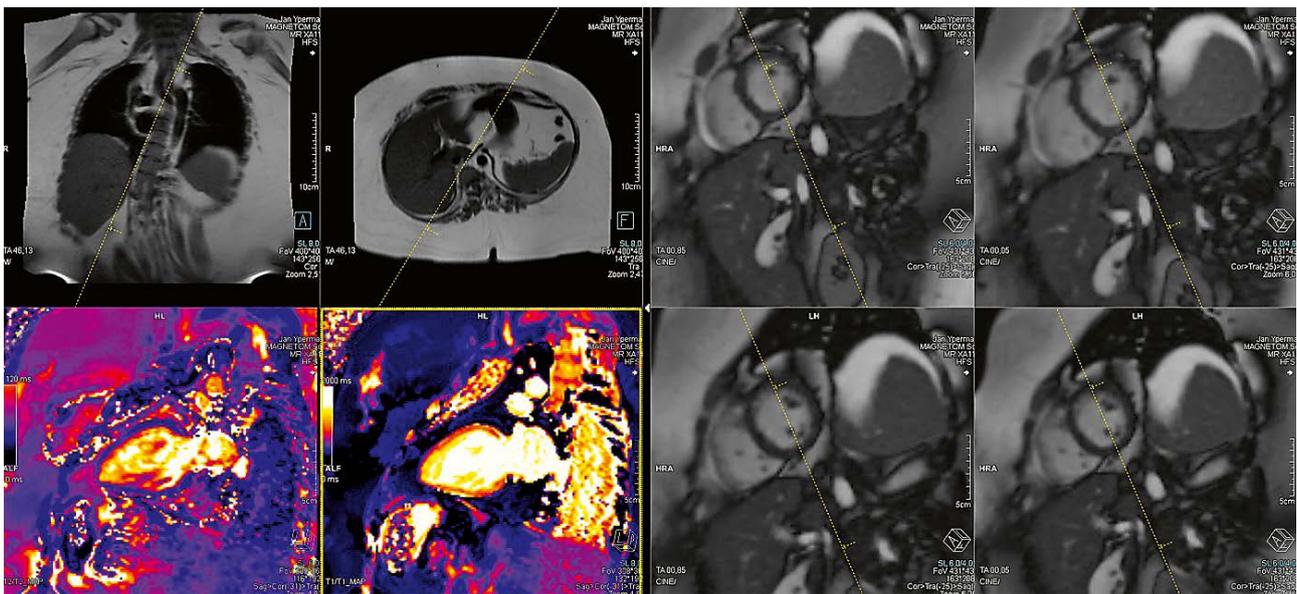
This very obese patient has atypical retrosternal pain. Transthoracic ultrasound of the heart was considered “non-diagnostic” due to obesity. The large bore of 1.5T MAGNETOM Sola is indispensable to accommodating this patient, as you can see in the left part of the image. The right part of the image shows free-breathing real-time Compressed Sensing Cardiac Cine with adaptive triggering. Acquisition time per slice varies (depending on the adaptive triggering) between 0.05 and 0.85 seconds.
